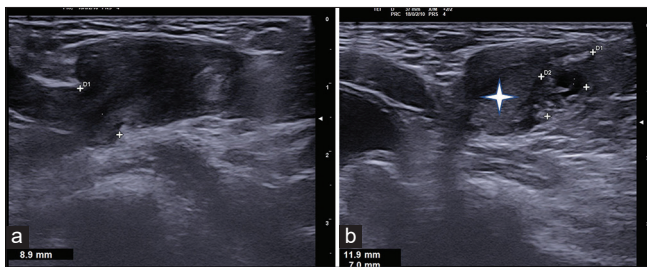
(a and b) Transverse ultrasound using a high-frequency probe through the left inguinal region shows a defect of size 8.9 mm (arrow in a) with herniation of the uterus (♦) and left ovary (small white arrow in b) through the canal of Nuck.
